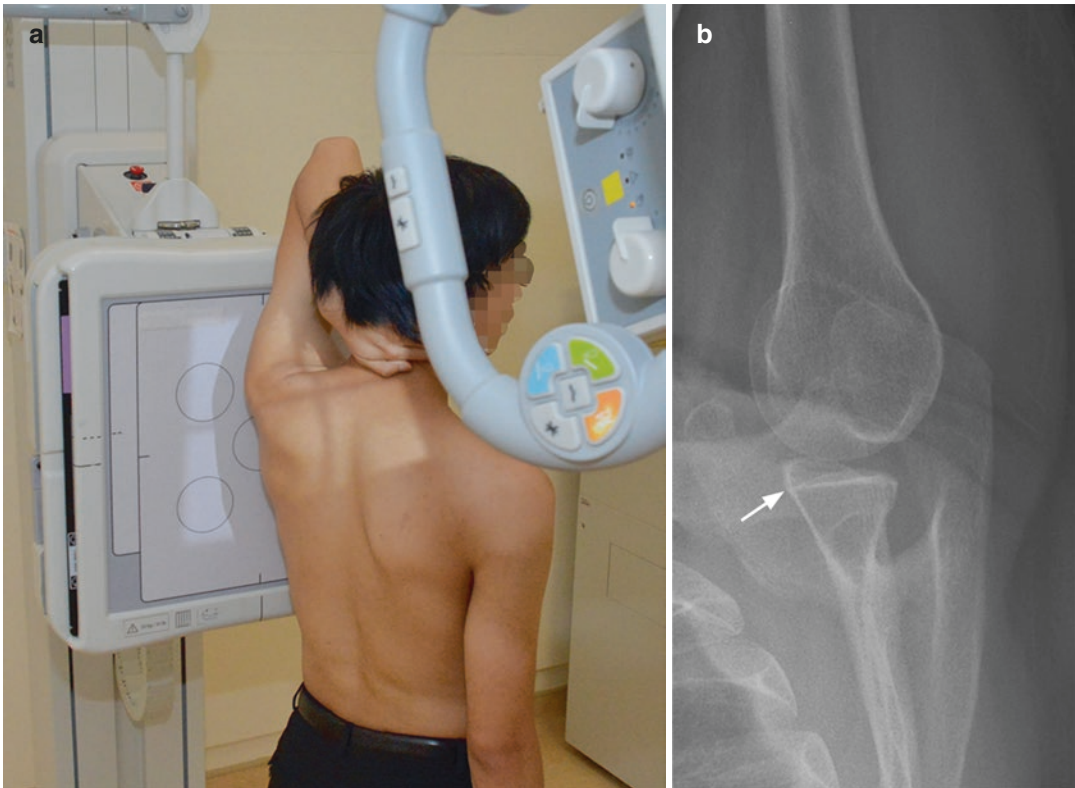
(a) Radiographic positioning for Bernageau view. (b) Bernageau view showing normal anterior glenoid rim (arrow)
